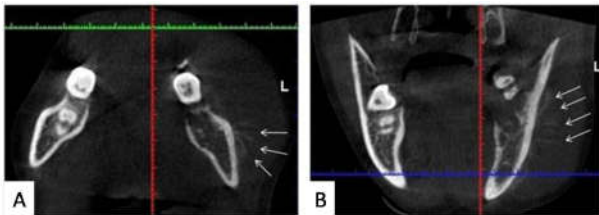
A & B showing, Axial & coronal section of CBCT at the level of molar-ramus region showing faint bony spicules radiating perpendicular to the outer cortex giving sun burst or sun-ray appearance.
